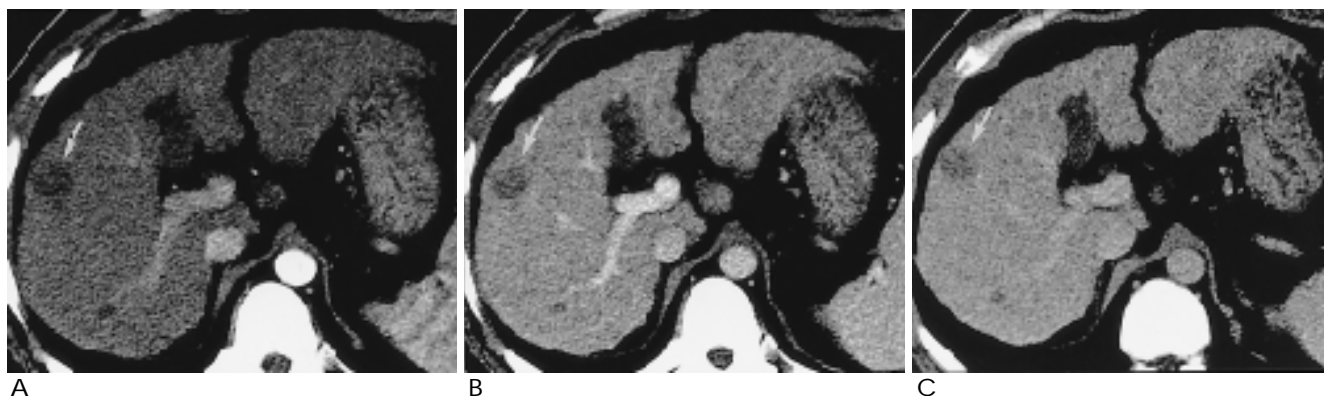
Helical CT scan shows homogeneous hypo-attenuation nodule (arrow) on hepatic arterial (A), portal venous (B), and equilibrium phase (C).
